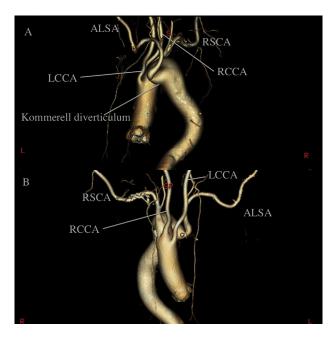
Preoperative computed tomography findings. (A) Left anterior oblique view, (B) frontal view. (ALSA = aberrant left subclavian artery; LCCA = left common carotid artery; RCCA = right common carotid artery; RSCA = right subclavian artery.)
